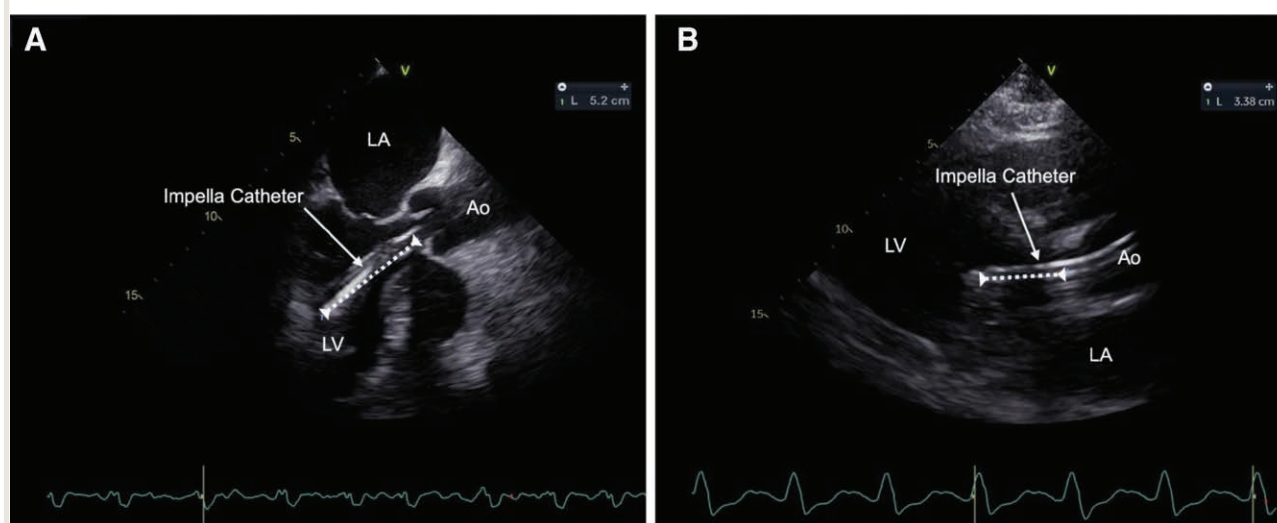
Impella (Abiomed Inc., USA) placement. (A) The Impella 5.5 should be inserted 5.0 cm into the left ventricle, measured from the aortic valve annulus (dashed line). A midesophageal long-axis view is shown. (B) The Impella CP should be inserted 3.5 cm into the left ventricle (dashed line). A parasternal long-axis view is shown.
